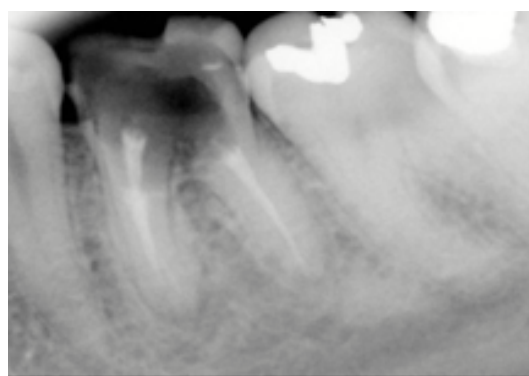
Radiograph showing root canal treated tooth with furcal defect
